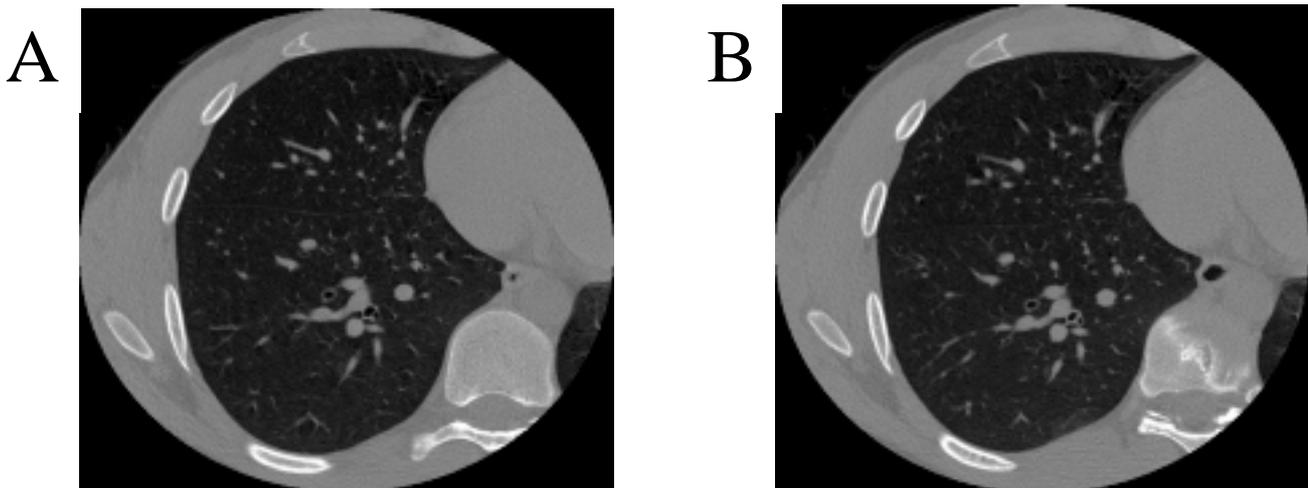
HRCT scans acquired in spiral mode, 1 mm collimation, pitch 1 of a 27 year old normal male subject (A) at baseline and (B) after methacholine challenge which induced a 30% decrease in FEV1. Lumen areas of airways marked (a) and (b) were measured to be 9.5 mm² and 7.3 mm² respectively at baseline and 6.3 mm² and 6.0 mm² after methacholine. Note the matching patterns of the pulmonary vessels, which ensure that the same regions of the airways are being compared.
